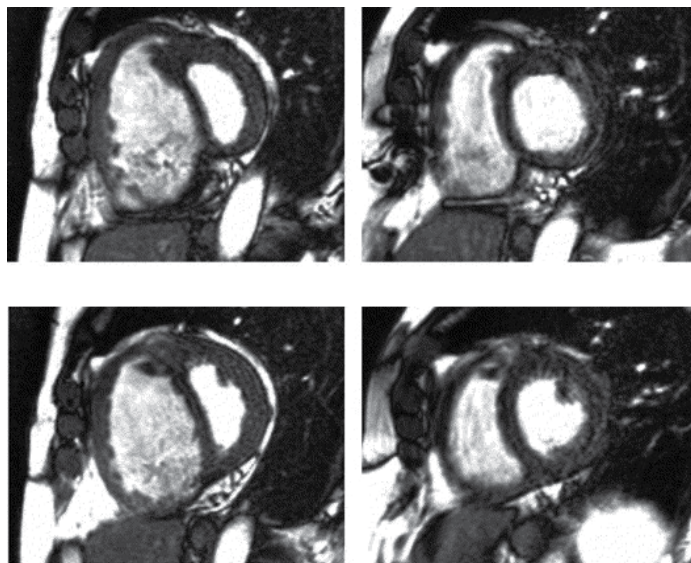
MRI short-axis cine images at basal (upper panel) and mid-ventricular (lower panel) level, before (A) and after (B) PEA (relative time 55% in the cardiac cycle). Note the encroachment of the interventricular septum into the LV before PEA and the restoration of the septal bowing to normal after PEA. Note also the reversal of RV hypertrophy and the normalization of the RV and LV volumes (Adapted from: Reesink et al., 2007)
